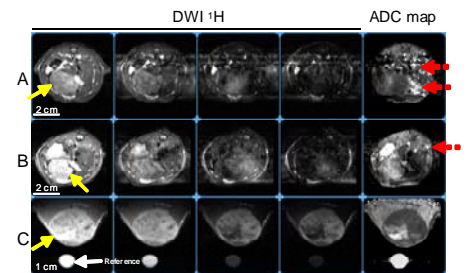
DWI and ADC maps of IH (A, B) and SC (C) HCCs at different b -factors (in s/mm^2): a – 0, b – 256, c – 945, d – 1679. HCC is marked by yellow arrows and the motion artifact is marked by the dotted red arrows on the ADC maps.
